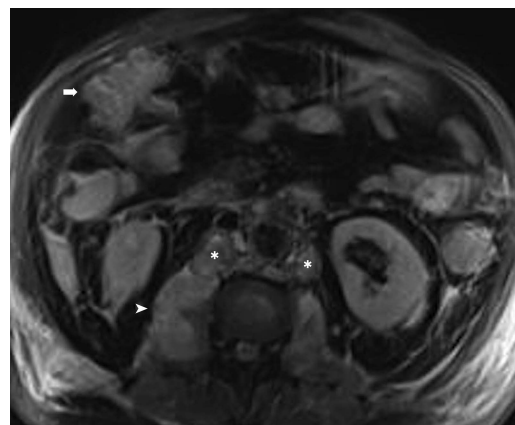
Axial T1-weighted fat-saturated MRI after gadolinium administration reveals an enhanced mass of the right psoas muscle (arrowhead), lumboaortic lymph node metastases (asterisks) and a huge, solid peritoneal implant at the right side of the great omentum (arrow).
